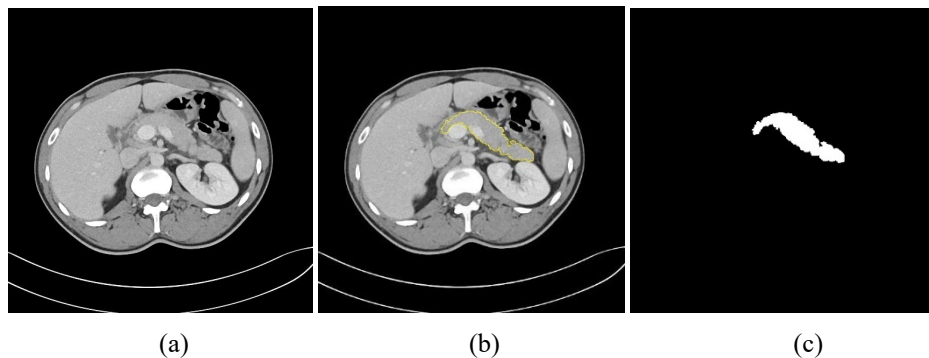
A CT image from SUMFH database (512x512 pixels): (a) Original image, (b) Labeled image, (c) Mask
